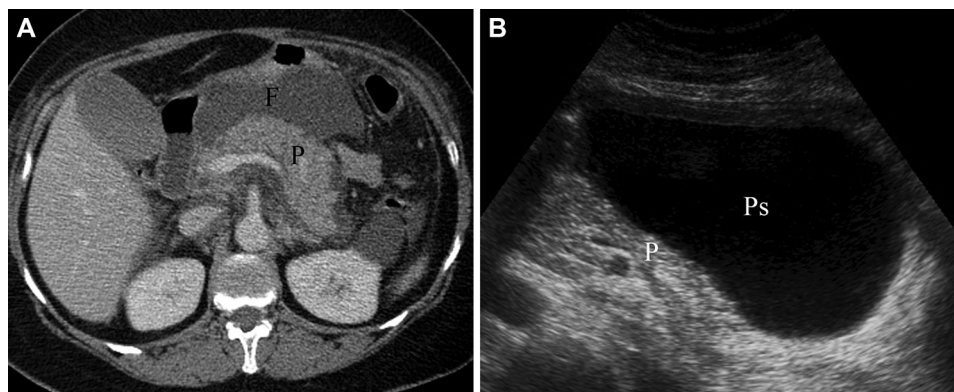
Evolution of a pseudocyst. Interstitial oedematous pancreatitis in a 64-year-old woman with gallstones. (A) A contrast-enhanced computed tomography (CT) image, obtained at admission, revealing acute peripancreatic fluid collection (F) predominantly collected in the lesser sac. (B) An ultrasound image of the same patient, obtained 5 weeks after the CT, showing the development of a pseudocyst (Ps) in the lesser sac. P = pancreas.
